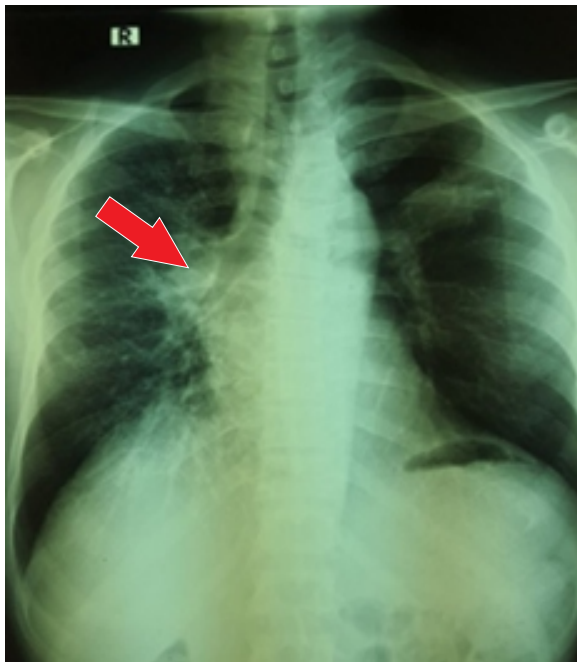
Chest X-ray with right hilar mass (red arrow) and ipsilateral volume impairment
